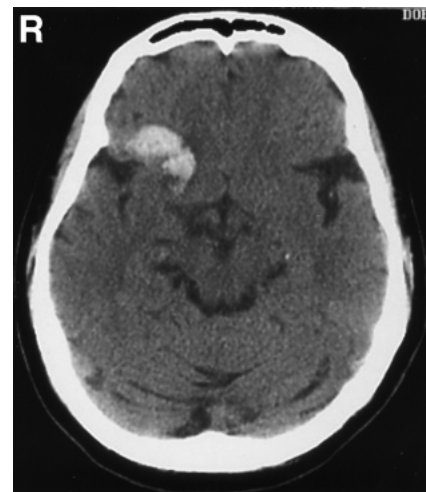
Computed tomography scan on admission showing hemorrhage within the treated nidus.
